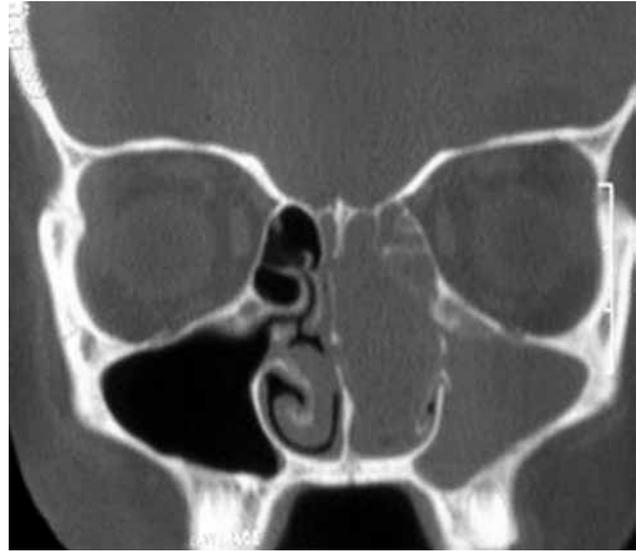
Coronal computed tomography scan showing homogenous mass in nasal cavity and maxillary sinus without bony destruction.
